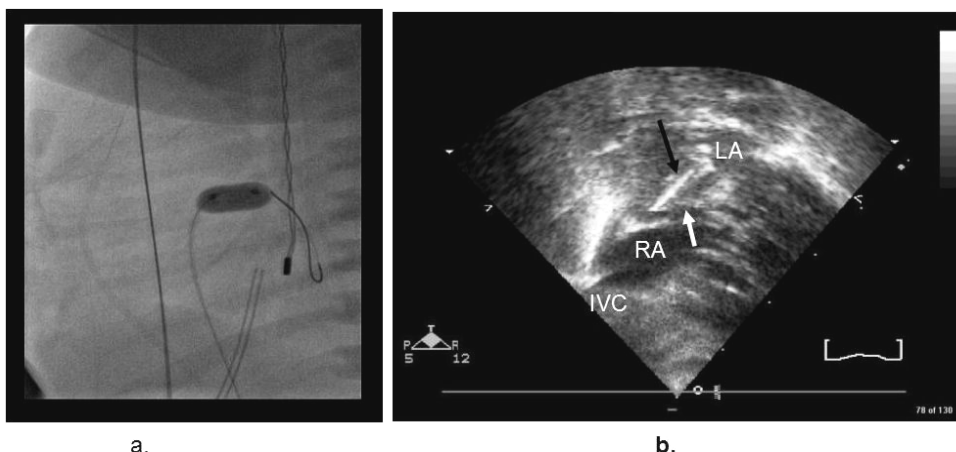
(a) Lateral fluoroscopic view of cutting balloon fully inflated in the atrial septum; (b) companion echocardiographic view showing balloon in atrial septum (white arrow). Note echogenic bright microtome visible along length of balloon (solid black arrow).
